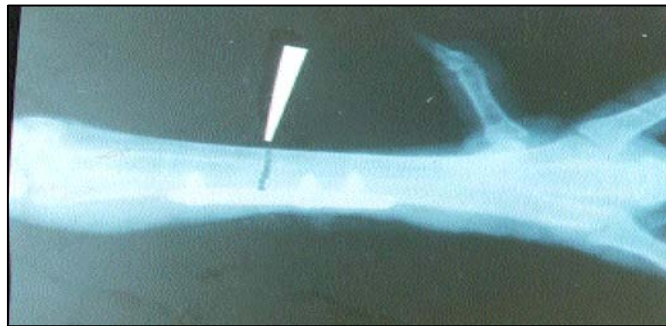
Radiographic view of reduced fracture gap of complete transverse fracture of tarsometatarsal bone of bird immediately after fixation with dynamic compression plate with cortical screw (indicated by arrow)
